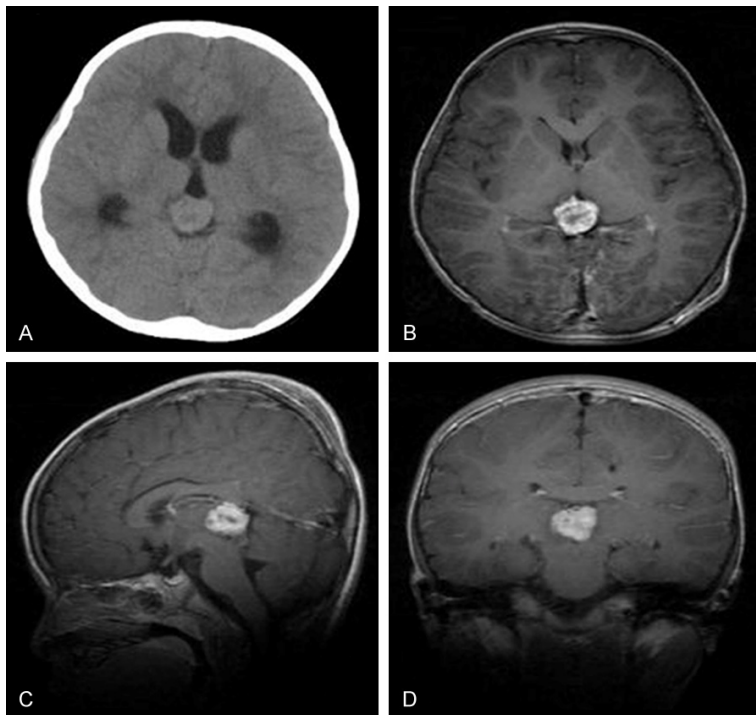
A: The tumor was located at posterior third ventricle and showed isodense on CT scan. B-D: MRI showed slight hypointense on T1-weighted sequences and displayed a strong contrast enhancement.
